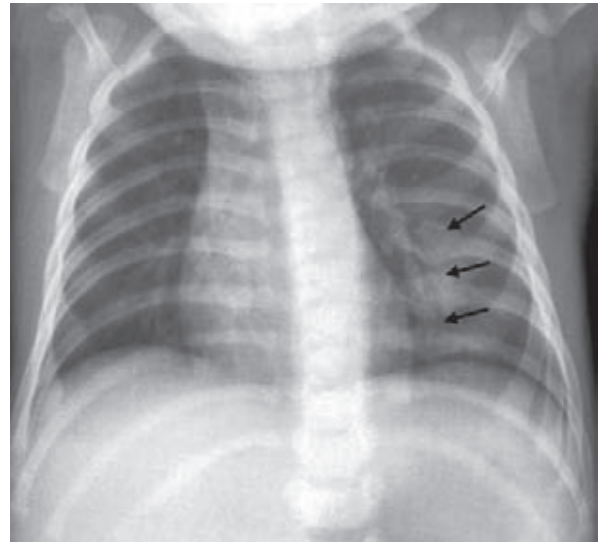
Frontal chest radiograph shows healing posterior rib fractures involving the left seventh, eighth and ninth ribs (arrows)
